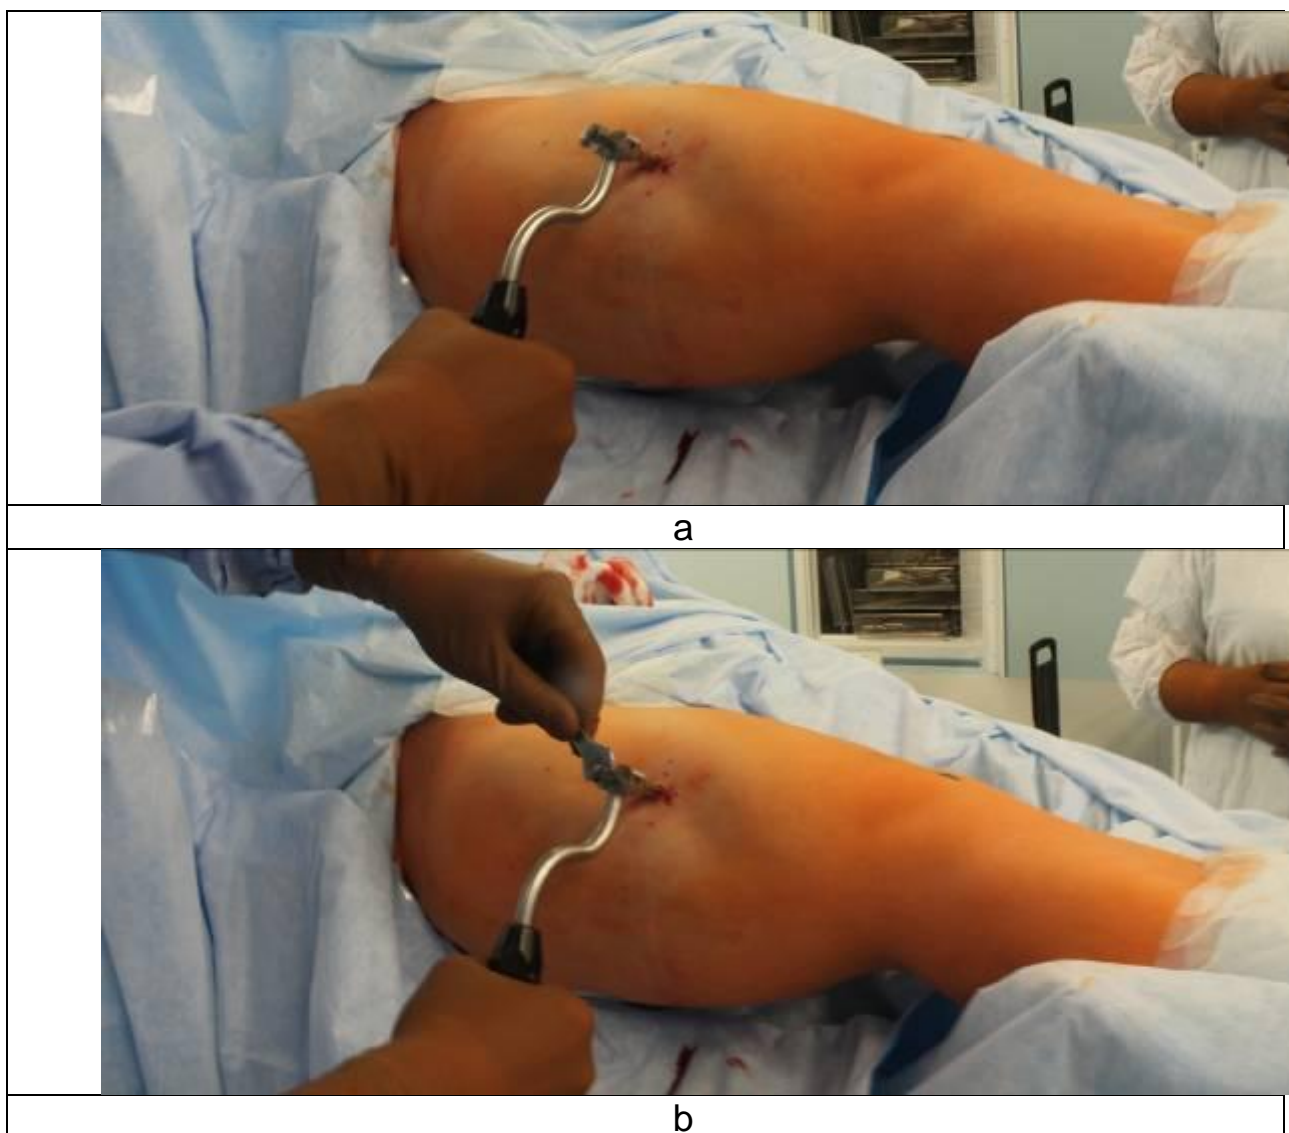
Removal of SUV-clamp: a – Instrument #2 is connected with T-shaped part of SUV-clamp; b – the nut is unfastened by wrench
